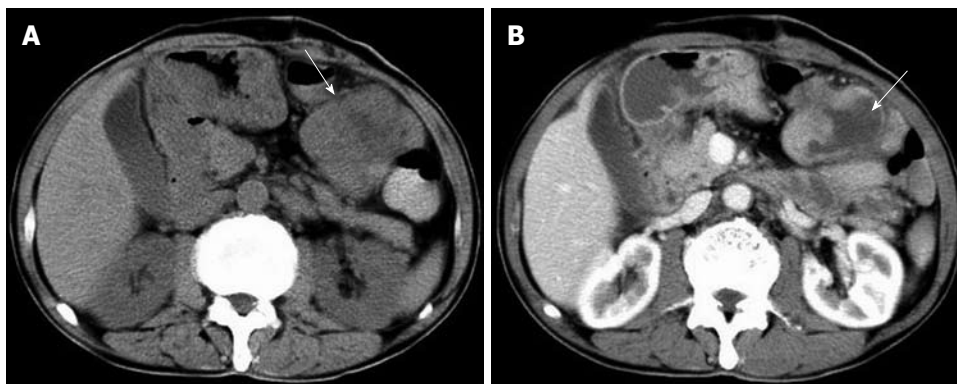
A 64-year-old male with superior mesentery malignant fibrous histiocytoma. A: Non-contrast computed tomography scan shows mass (arrow) in the peritoneal cavity of 33 HU with a clear margin and central area of hypodensity; B: Contrast-enhanced scan venous phase shows mild enhancement with more pronounced central necrotic zone (arrow).
